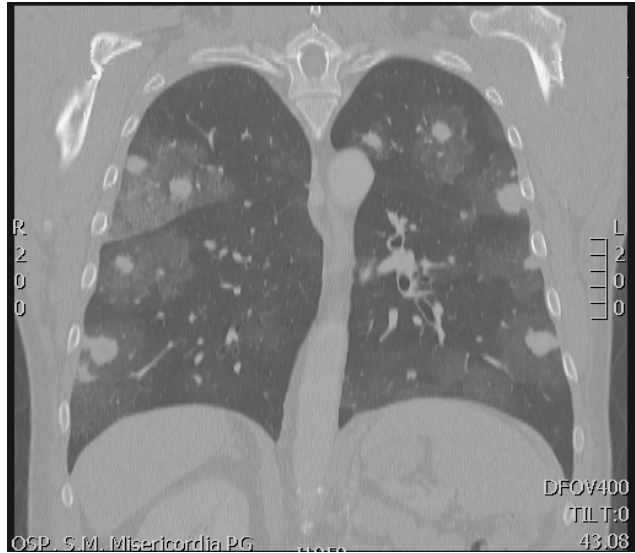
CORONAL CT SCAN showing several nodular opacities of the lungs with ground glass opacity and tree-in-bud signs
